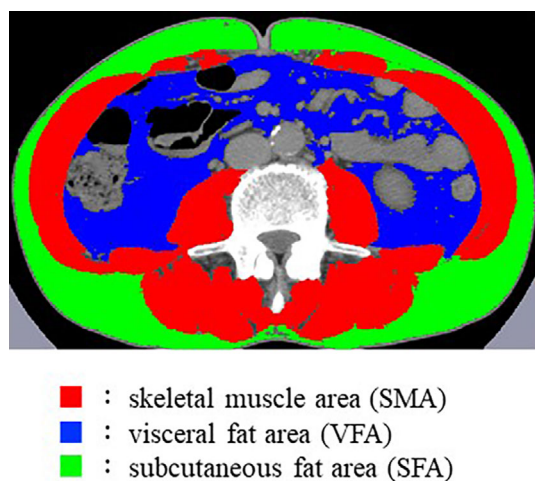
Cross-sectional computed tomography images at the umbilical level to measure body composition areas. Red, blue, and green areas indicate skeletal muscle, visceral fat, and subcutaneous fat area, respectively. SMA: skeletal muscle area, VFA: visceral fat area, SFA: subcutaneous fat area
